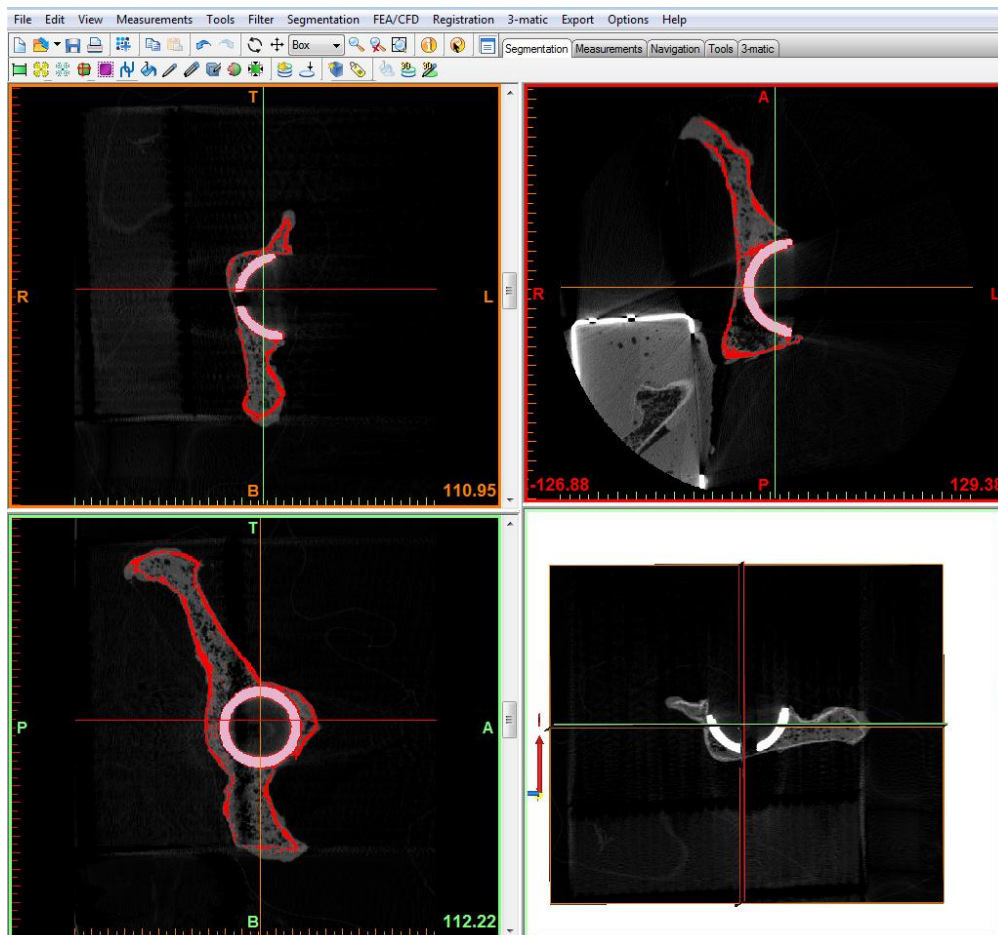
Figure XLIV. High resolution CT scan of the hemi-pelvis following acetabular cup implantation and mechanical testing. Cortical bone and acetabular cup mask surfaces are automatically generated using density segmentation in Mimics.
